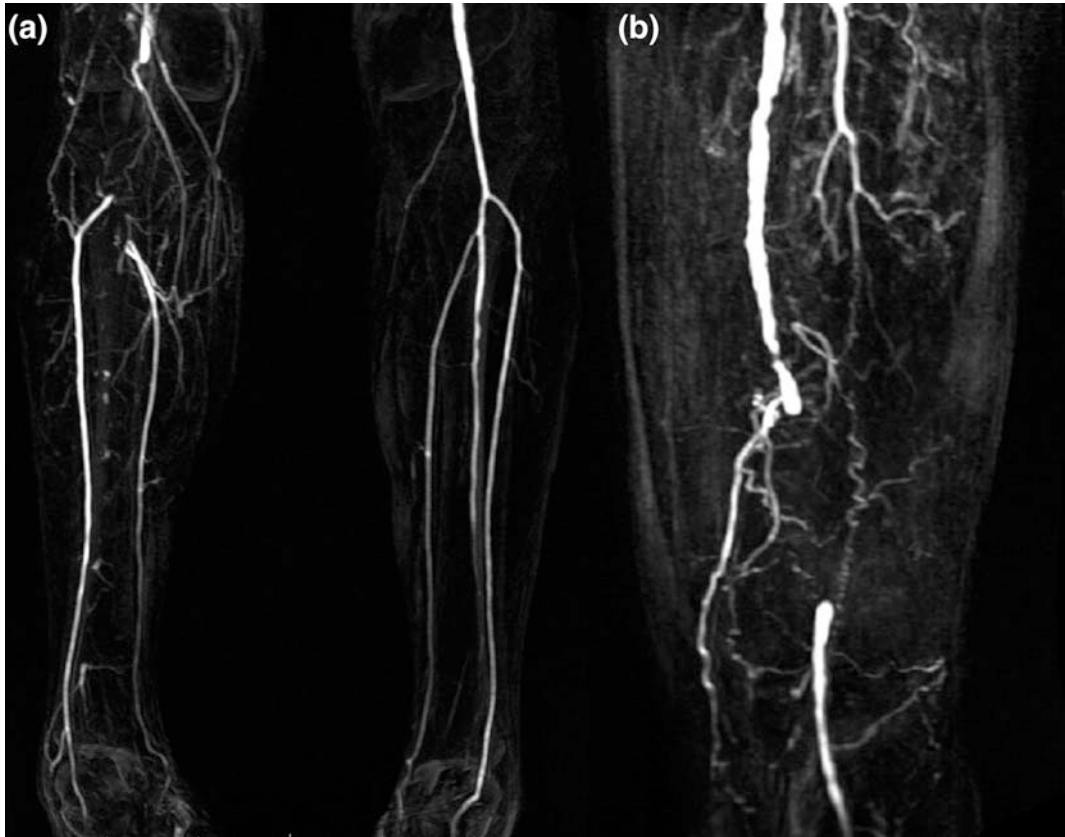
Right popliteal artery occlusion in a patient with lower limb claudication. a Sagittal T1-weighted CE-MRA. b MIP reconstruction particular on right
